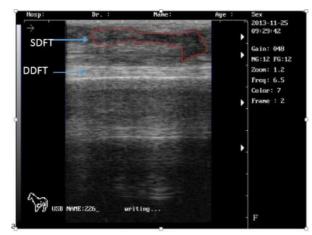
Ultrasound longitudinal image for the tendons of control group at 30 post operatively showing the presence of marked fluid in SDFT and absence of normal fiber pattern, and short, croppy fiber.
